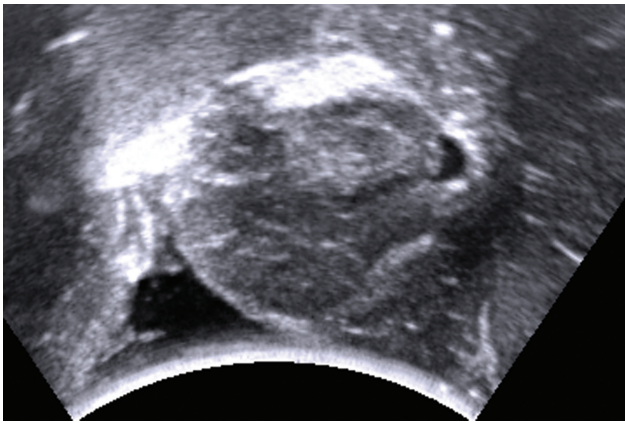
Ultrasound examination of the hippocampus (images oriented similarly to coronal magnetic resonance imaging scans).
